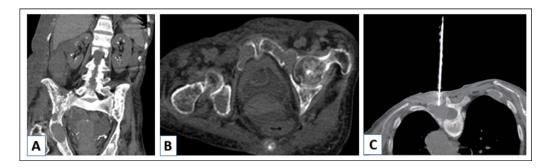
Abdominal pelvic CT scan coronal section (A) showing renal lithiasis with diffuse osteolytic lesions of the pelvis. Axial section bone (B) showing lytic ischio pubic lesions with cortical rupture. (C) CT-guided bone biopsy of D5.
